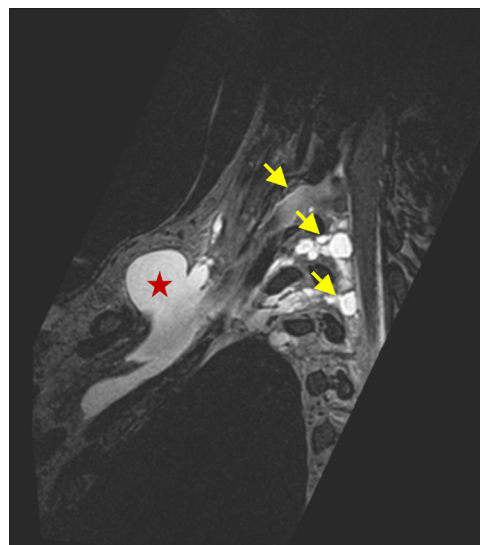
Brachial plexus MRI (reformatted T2-3D sequence, with oblique axial and oblique coronal slices) revealing the presence of pseudomeningoceles (yellow arrow) from the C6 root to the D2 root (coronal plane) and extension to a collection in the right upper limb (red star).
